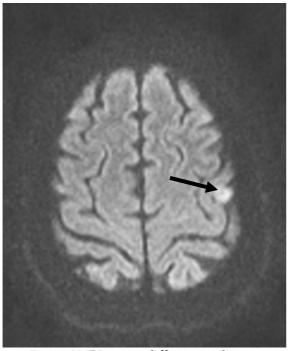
MRI exam – diffusion axial sections pre-contrast:
